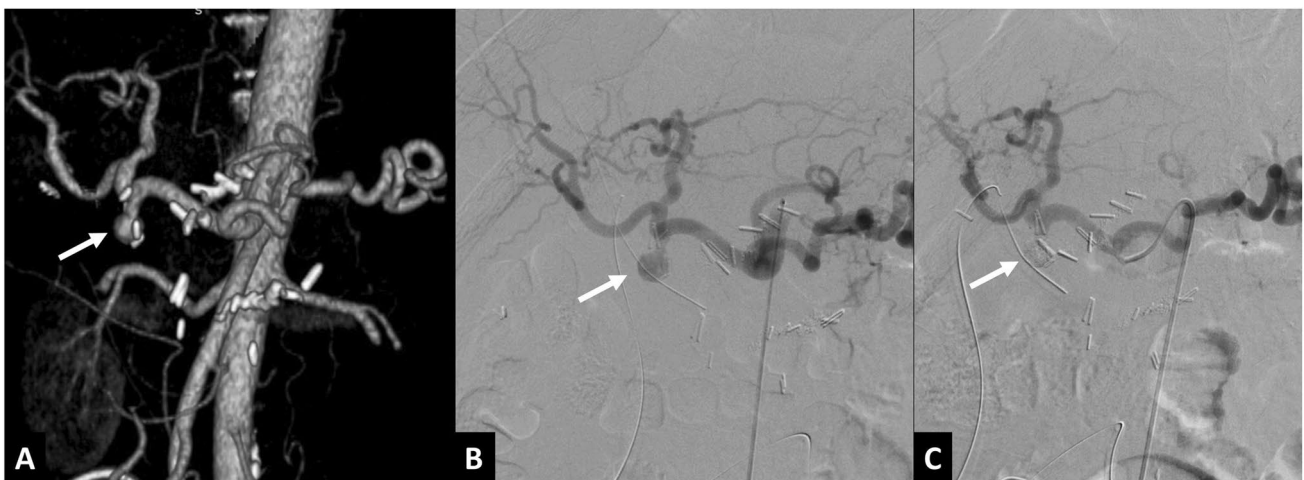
Fifty-nine-year-old male who underwent pancreatoduodenectomy for pancreatic carcinoma, came with hematemesis and bleeding from drainage catheter six days after the surgery. A Volume rendered computed tomography (CT) angiography image shows a pseudoaneurysm arising from the gastroduodenal artery stump (arrow). B Digital
